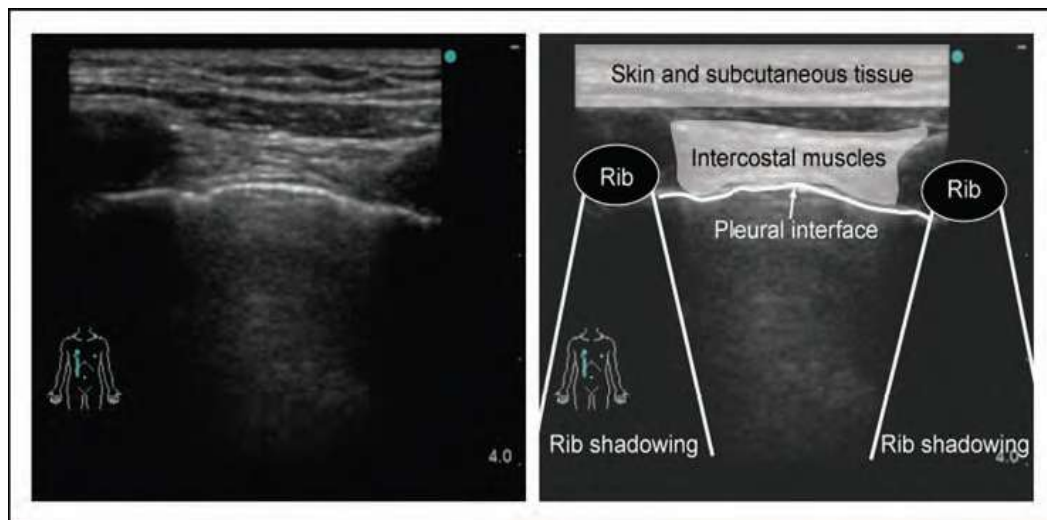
Typical lung ultrasound image showing normal ribs (Piette et al, 2013).
